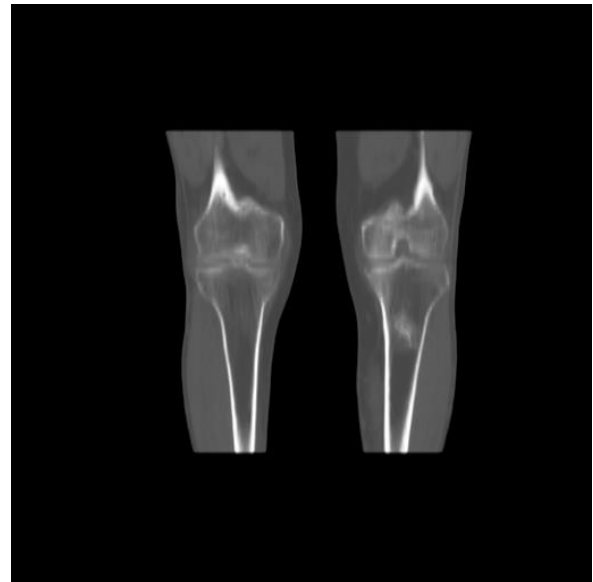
Coronal view of CT (B, bone window), of the inferior limb at knee height. There is a region of increased uptake of ^{11}C -choline in the area of bone thickening evident in the CT scan.
